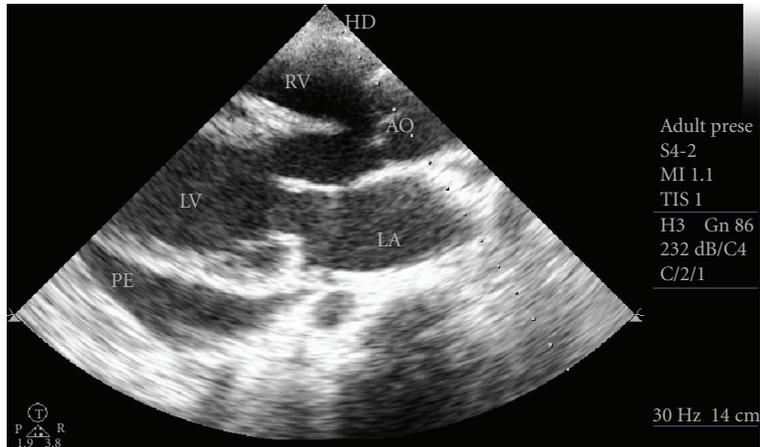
Parasternal long axis view depicting nonrestrictive, subaortic VSD, thick mitral valve leaflets and pericardial effusion.
